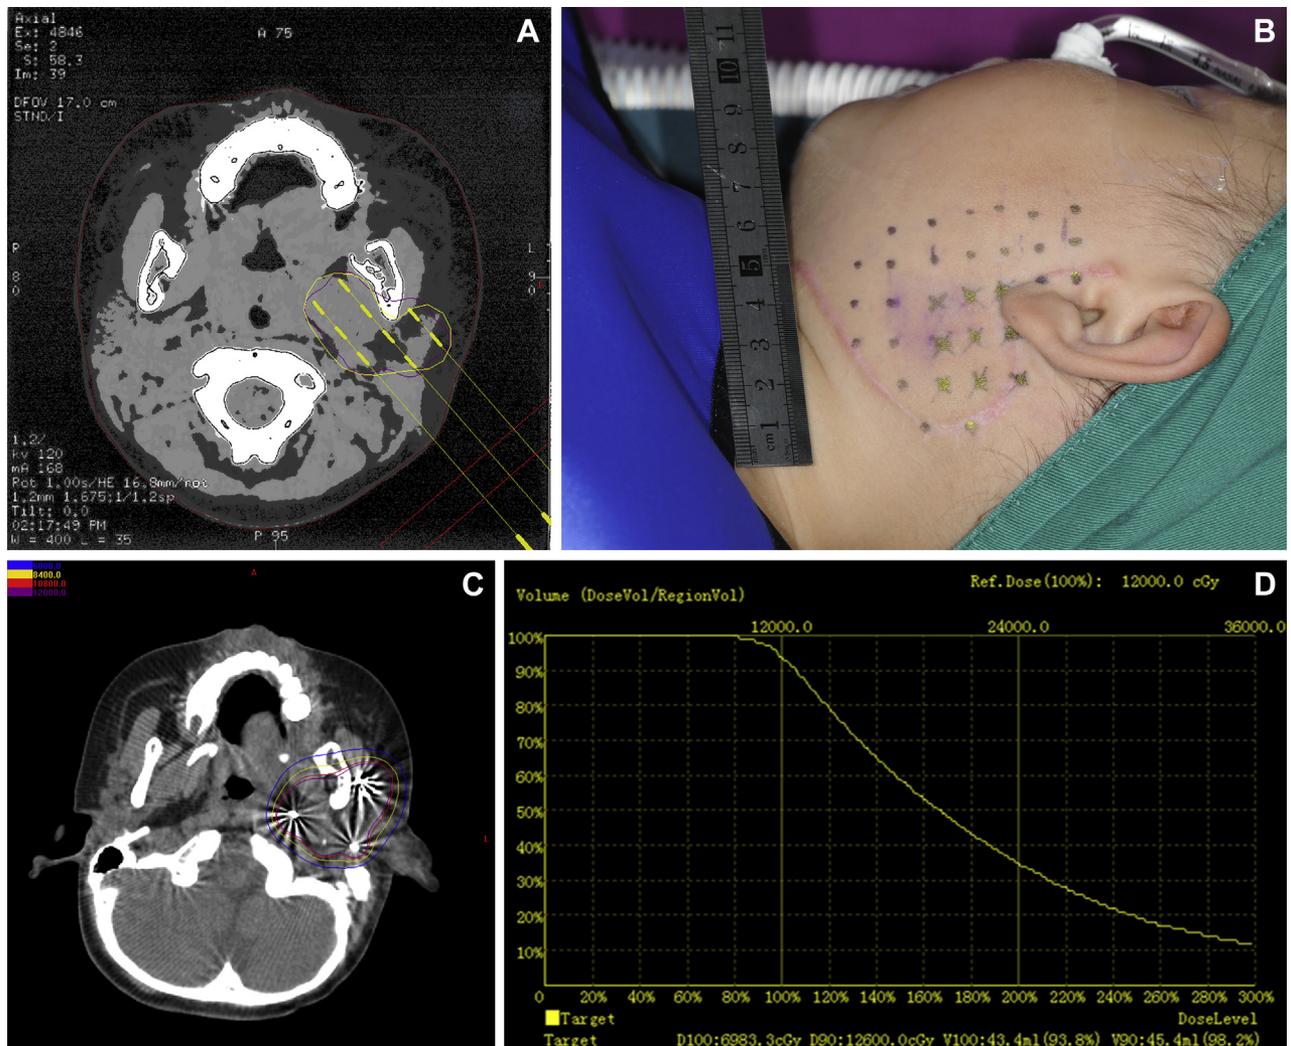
A, Preoperative plan using the Brachytherapy Treatment Planning System. B, Permanent implantation under general anesthesia was guided by computed tomography according to the plan. C, Postoperative quality verification using the Brachytherapy Treatment Planning System. D, Dose and volume histogram of quality verification.
